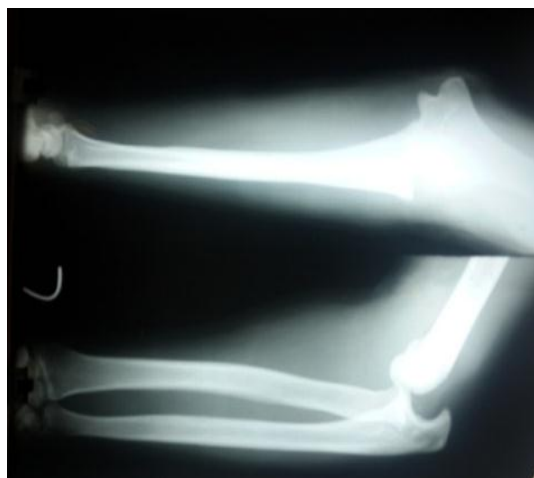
Anteroposterior and lateral radiographs of patient 1 demonstrating chronic posterolateral elbow dislocation 20 weeks after the injury.
